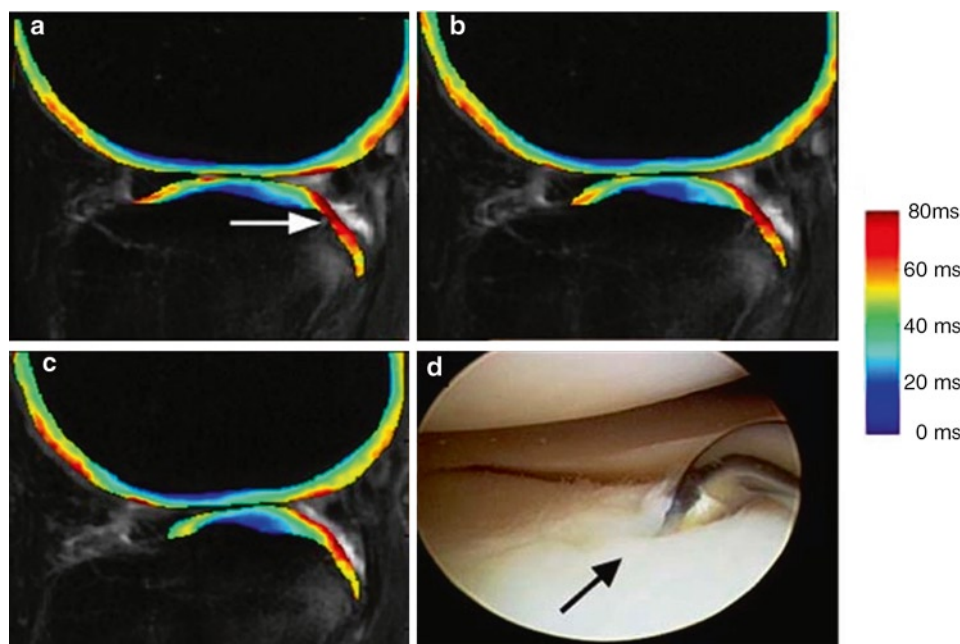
(a–c) Color-coded $T_{1\rho}$ map overlaid on 3-T magnetic resonance images, demonstrating the increased $T_{1\rho}$ relaxation times along the posterolateral aspect of the tibial plateau, at the site of the tibial plateau bone bruise (white arrow). The mean $T_{1\rho}$ value of the cartilage directly over the bone bruise was 60.2 ± 13.7 ms, whereas the mean $T_{1\rho}$ value of the remaining
